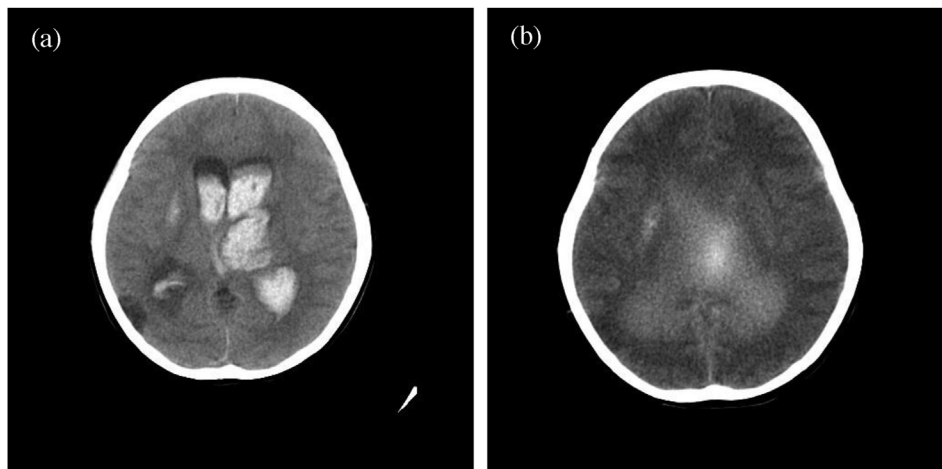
a) CT image shows the left thalamic bleeding spread into ventricle, the hydrocephalus, the right putamen calcification and old cerebral infarction on right occipital lobe. b) CT image shows the residual hematoma and diffuse hypoxic encephalopathy.
